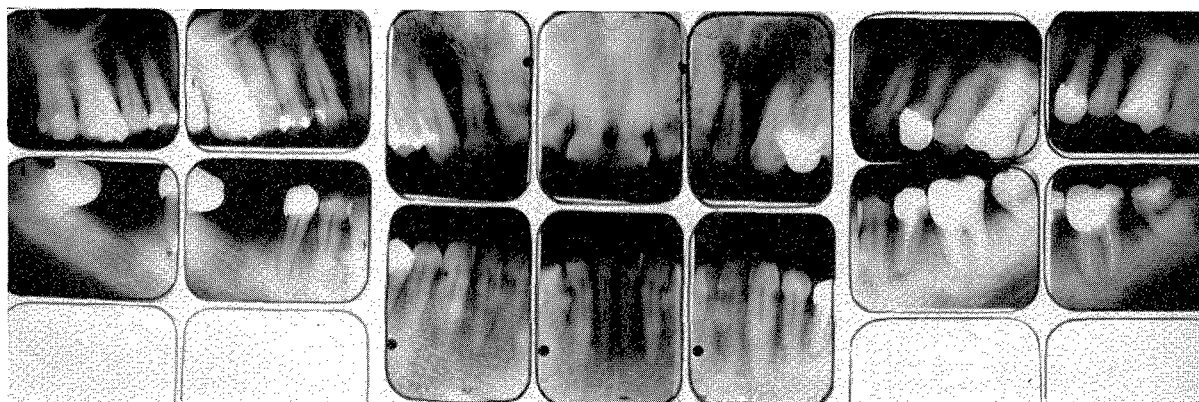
Roentgenograms of the patient shown in Figs. 52 and 53. These were taken in 1949 when I first undertook this patient's dental treatment. He was then 59 years old.
